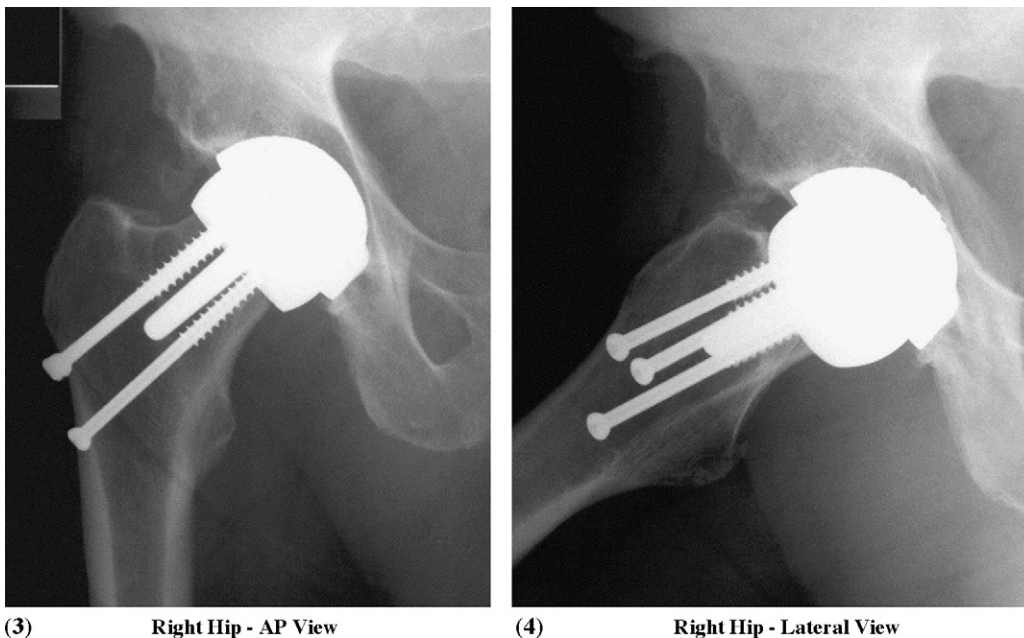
Radiographs demonstrating the undisplaced basi-cervical peri-prosthetic fracture.
